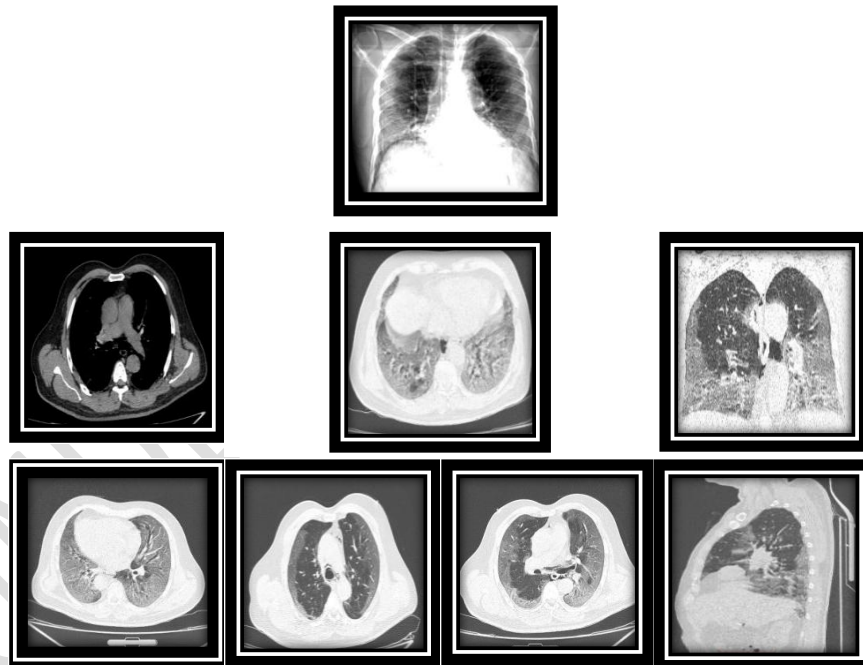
40 year old male, who had fever for ten days with progressive coughing and shortness of breath. Saturation at admission was 70%. X – ray finding “posteroanterior (PA) chest x- ray shows bilateral ground-glass opacities with peripheral predominance. CT finding “ bilateral multi-lobe symmetrical ground-glass opacities with a posterior and peripheral predominance, no significant enlarged lymph nodes, no pleural effusion. 50% of the lungs are involved. CO-RAD 4 likely COVID-19 and RT – PCR positive .
